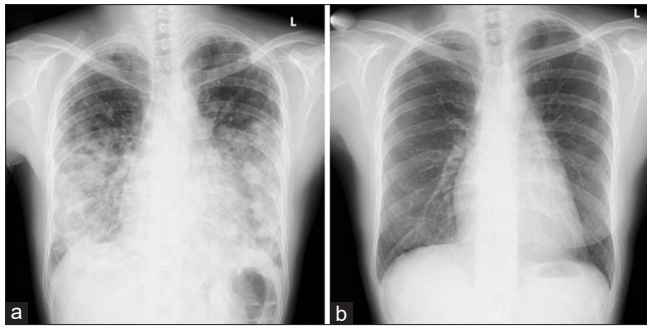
Chest X-ray before and after chemotherapy. (a) Before chemotherapy, (b) after chemotherapy
